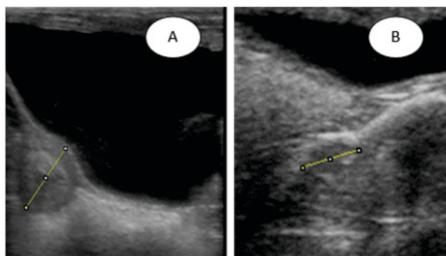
The ultrasound images of the ovary on group K+(A) and KP (B). The yellow arrow shows that there is a follicle development with various sizes.
